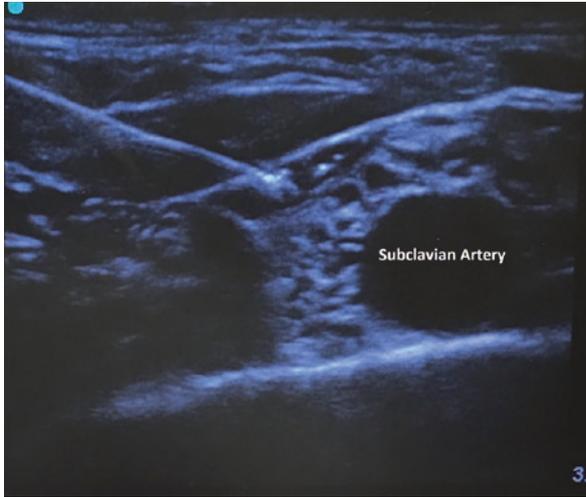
Ultrasound image of the brachial plexus in the supraclavicular location, a needle is seen injecting a pool of local anesthetic
